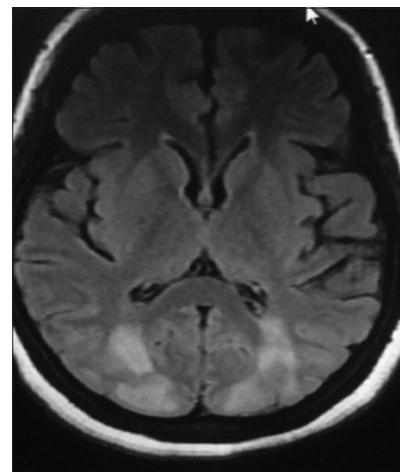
MRI images showing vasogenic oedema in occipital lobe
